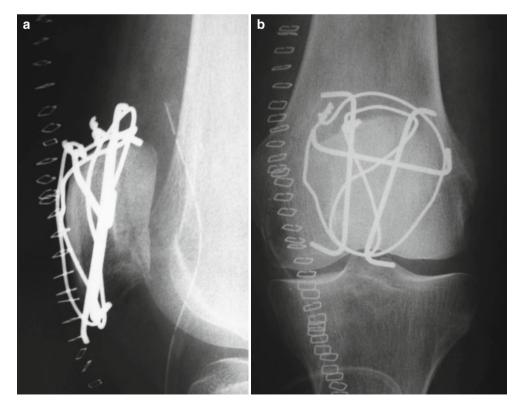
Postoperative lateral (a) and AP (b) radiographs following tension band wiring of a patella fracture
